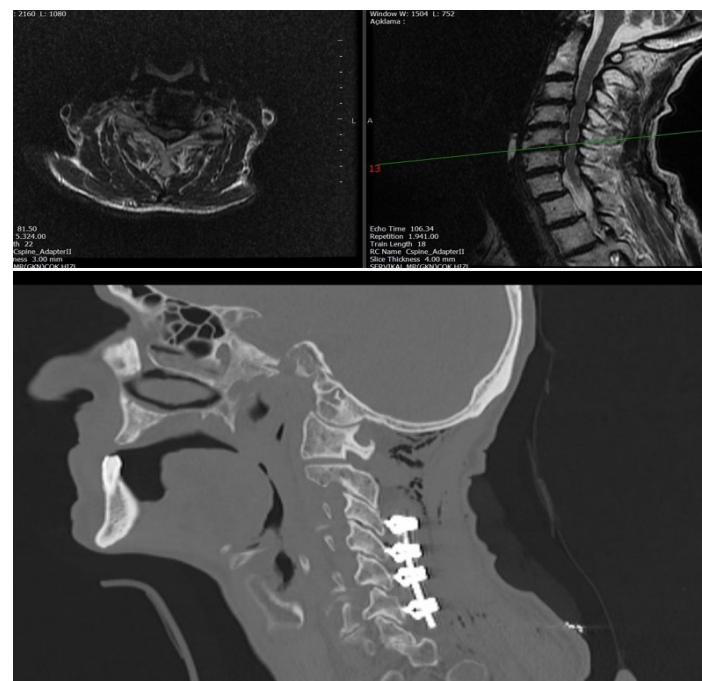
Preoperative MRI and postoperative CT images of a patient treated with posterior decompression
